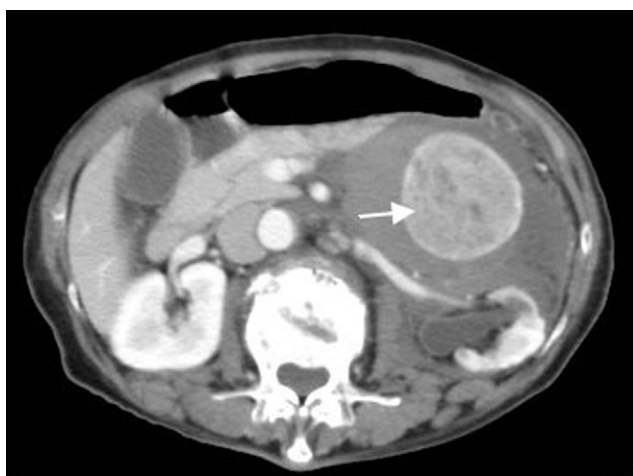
Abdominal computed tomography revealed an $8 \times 5 \times 4.5 \text{ cm}$ mass (arrow) with hematoma over the left retroperitoneum space anterior to the left kidney.
